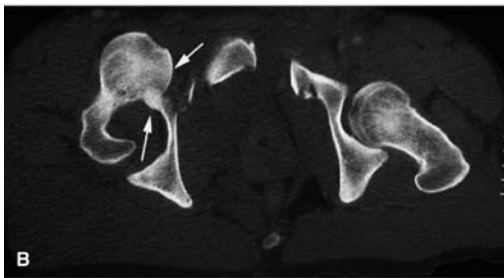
Anterior hip fracture-dislocation. The initial AP radiograph (A) shows the right leg to be externally rotated and the superior acetabulum to have a discontinuous margin due to an accompanying acetabular fracture. The CT scans, both axial (B) and 3D reconstructions (C), show the anterior dislocation of the femur, with both acetabular fracture and impaction fracture of the femoral head.
